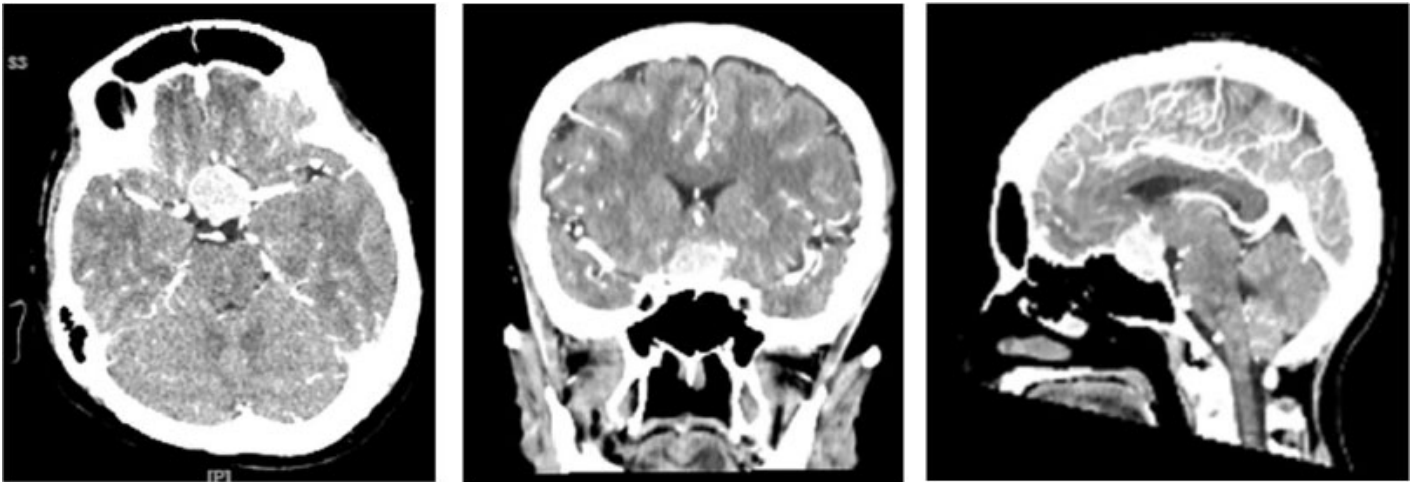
CT Scan examination shows that there is an extra-axial supratentorial mass with heterogeneity density that is pressing the optic chiasm superiorly, suggesting the pituitary macroadenoma (red arrow).
